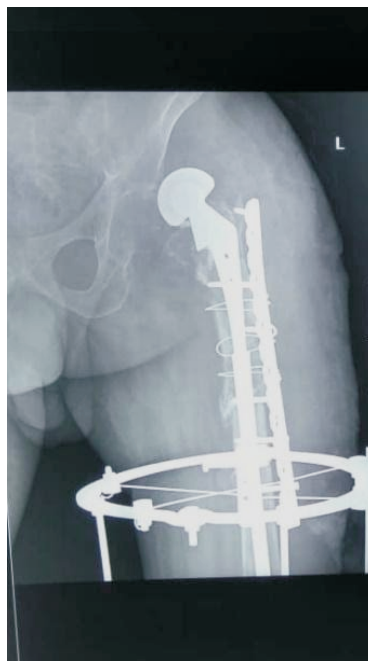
Post-op plain radiograph of patient 1 with dislocated prosthesis
